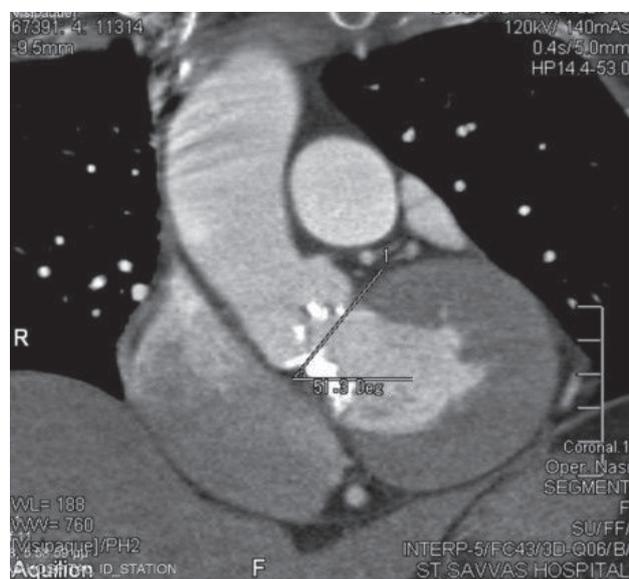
The atrioventricular angle is determined from the original CT coronal view, namely by determining the angle of the horizontal plane at the level of the ventricle and annulus angulation.
